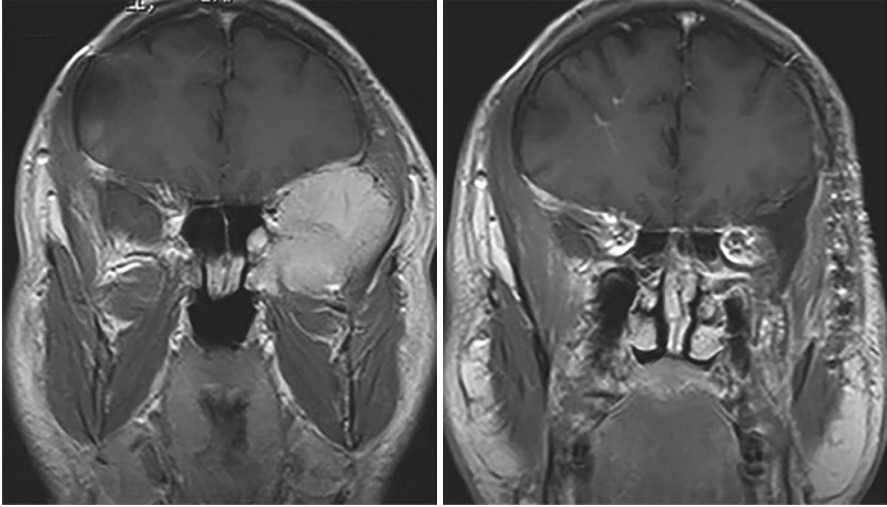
Case No 1. Contrast MRI T1 weighted in coronal section, showing an enhancing tumor that is invading the orbit and the left ITF (left). The tumor was completely excised with a ZTMA (right)
